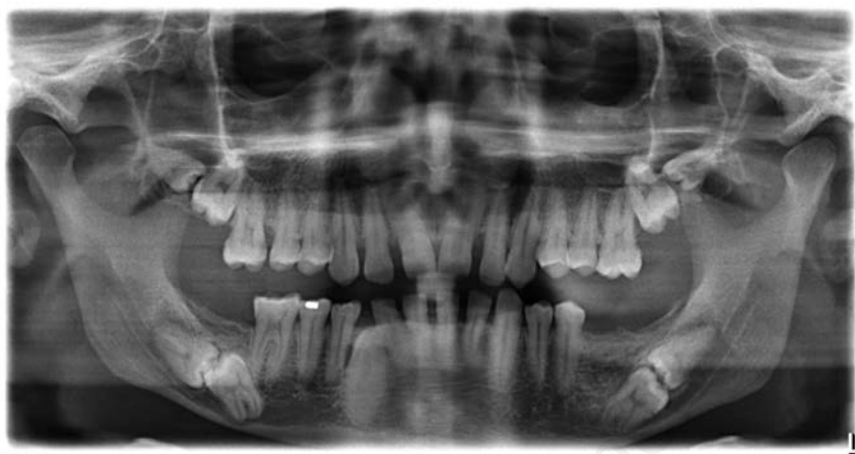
Panoramic radiograph showing bilateral mandibular kissing molars.
